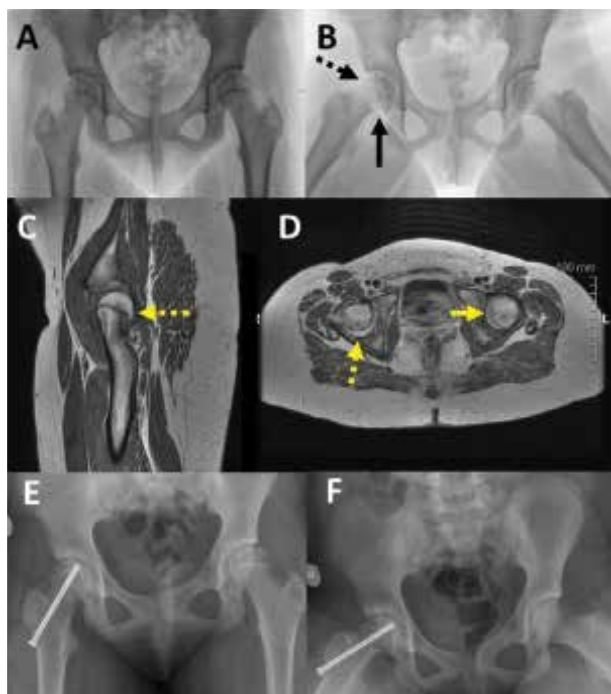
Valgus SCFE in a girl complaining of a painful right hip. Her sister presented a typical (varus) SCFE, which was addressed with in situ pinning a few weeks before. A. The femoral neck is tilted medially (valgus) and the femoral head posteriorly and laterally. B. The diagnosis is clear on the frog lateral pelvis projection, showing the small femoral head-neck offset (dashed arrow) with respect to the left hip and the apposition of new bone in the posteroinferior aspect of the neck metaphysis of the R hip (continuous arrow). Hip MRI (C, D) confirms the posterior version of the epiphysis (dashed arrow) of the R hip compared to the epiphysis of the asymptomatic contralateral hip (continuous arrow). The slip is stabilized in situ by means of one cannulated 6,5 mm screw (E,F). The patient is asymptomatic
